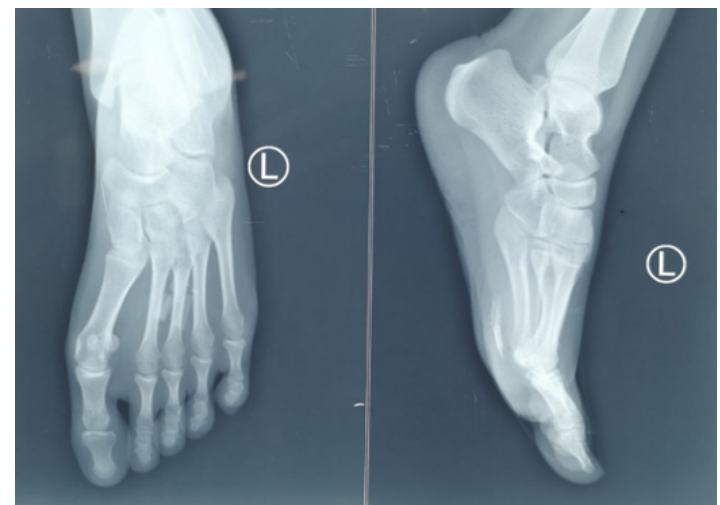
X-ray Left foot showing radiopaque foreign bodies in plantar aspect
